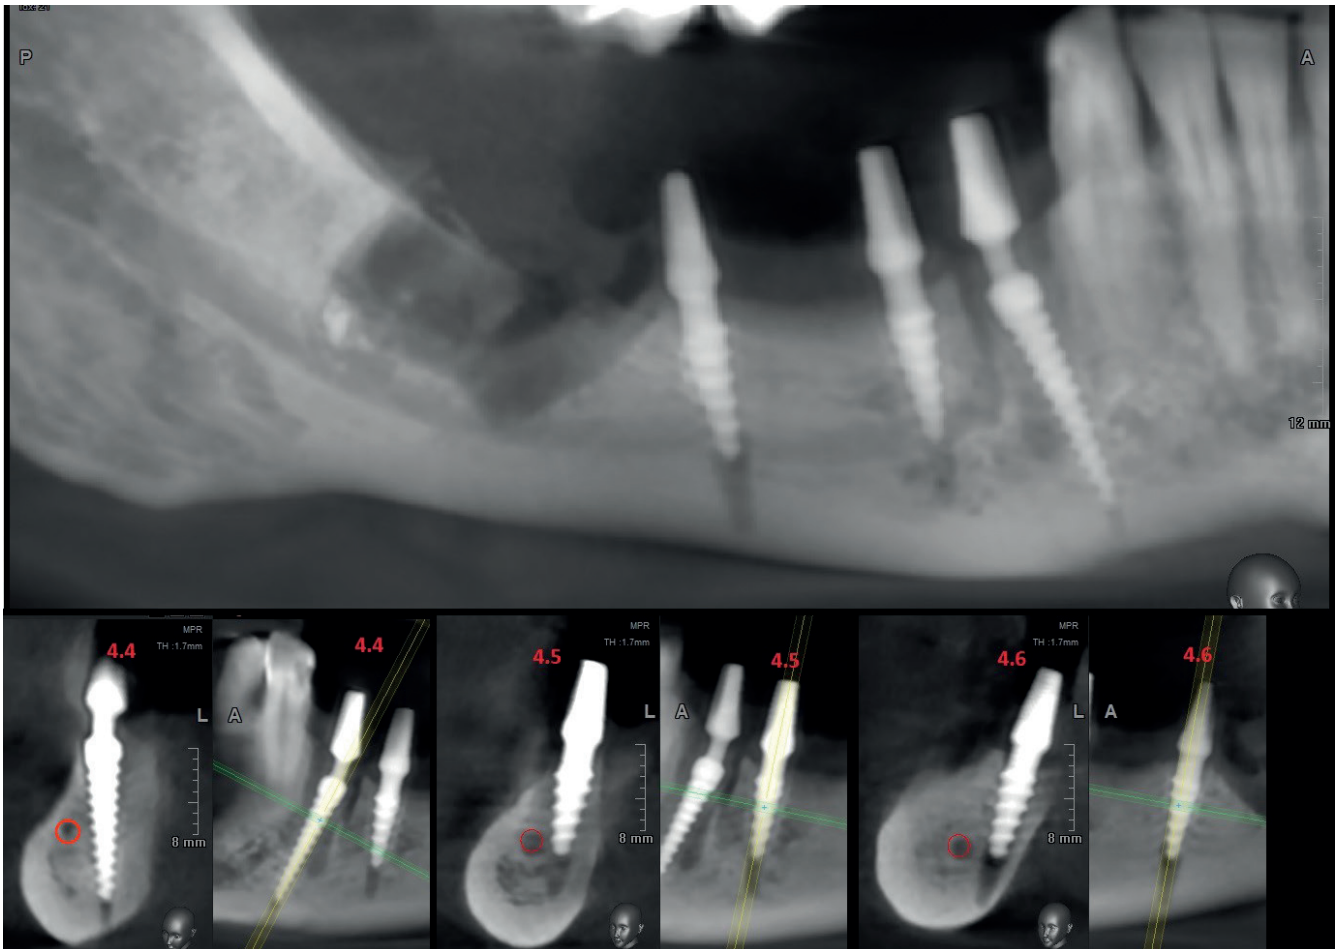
Reformatted CBCT scan, panoramic view. Patient S., born in 1972, 2 days after implantation. Teeth 44, 47, 48 extracted. Graphic visualization of the mandibular canal. Installation of 3 single-piece implants on the lingual side of the mandible “by-passing” the inferior alveolar nerve.
